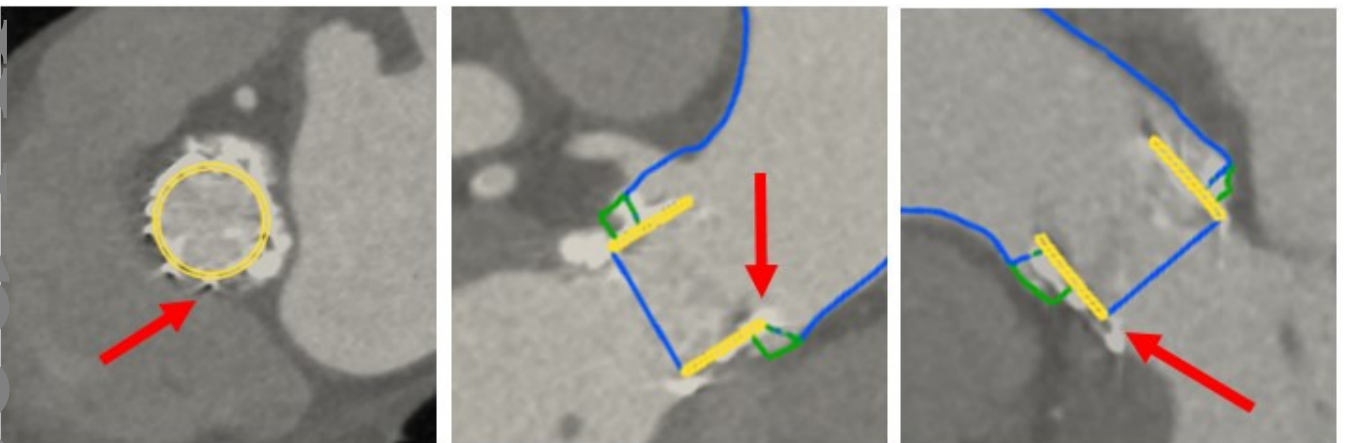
Comparison of the reconstructed geometries (yellow: SLC; green: LZ; blue: fluid domain) with 5-year follow-up CT scans of patients DEG1 (above) and DEG3 (below). The stent in the background grayscale CT image can be identified by the alternate white-black regions (see the red arrows).
